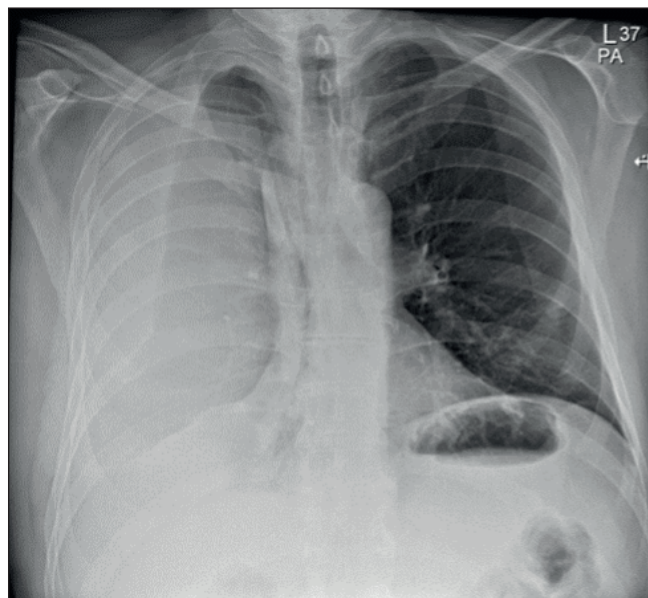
Chest X-Ray on admission, showing a peripheral pleural opacity with smooth borders
